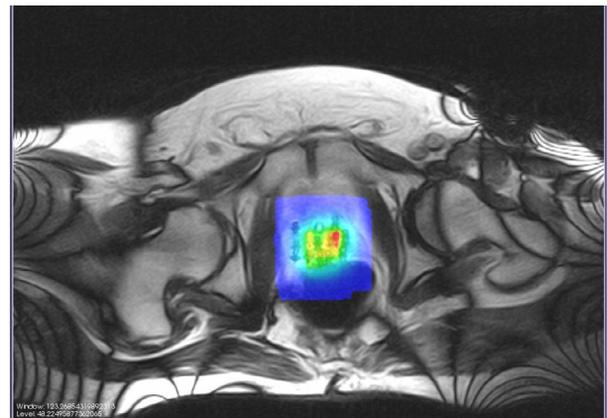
The fusion of MR images and optimized dose map.
